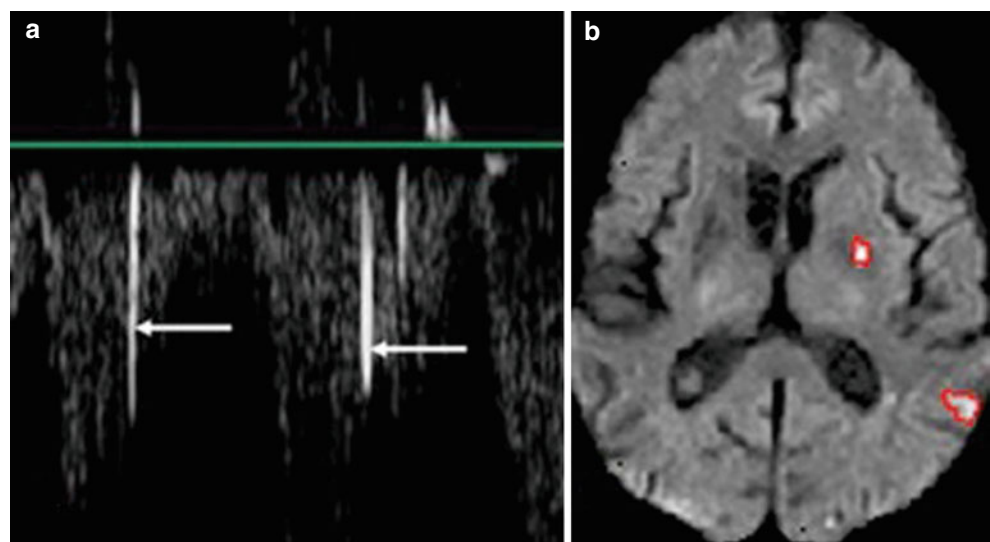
Microemboli: panel (a) identified on Duplex velocimetric complexes (white arrows); panel (b) microinfarcts seen on diffusion-weighted magnetic resonance imaging
